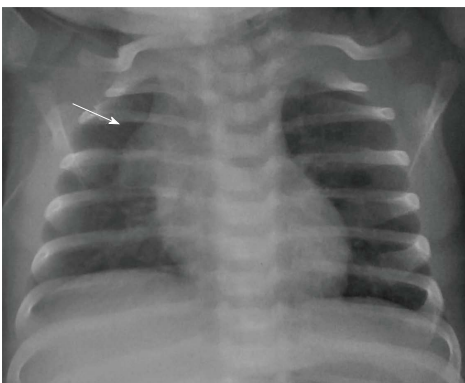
Frontal chest radiograph of a 2-mo-old girl with cough. The thymus gland is prominent but normal. Note the impression of the anterior ribs on the thymus producing the "wave sign" (arrow).
